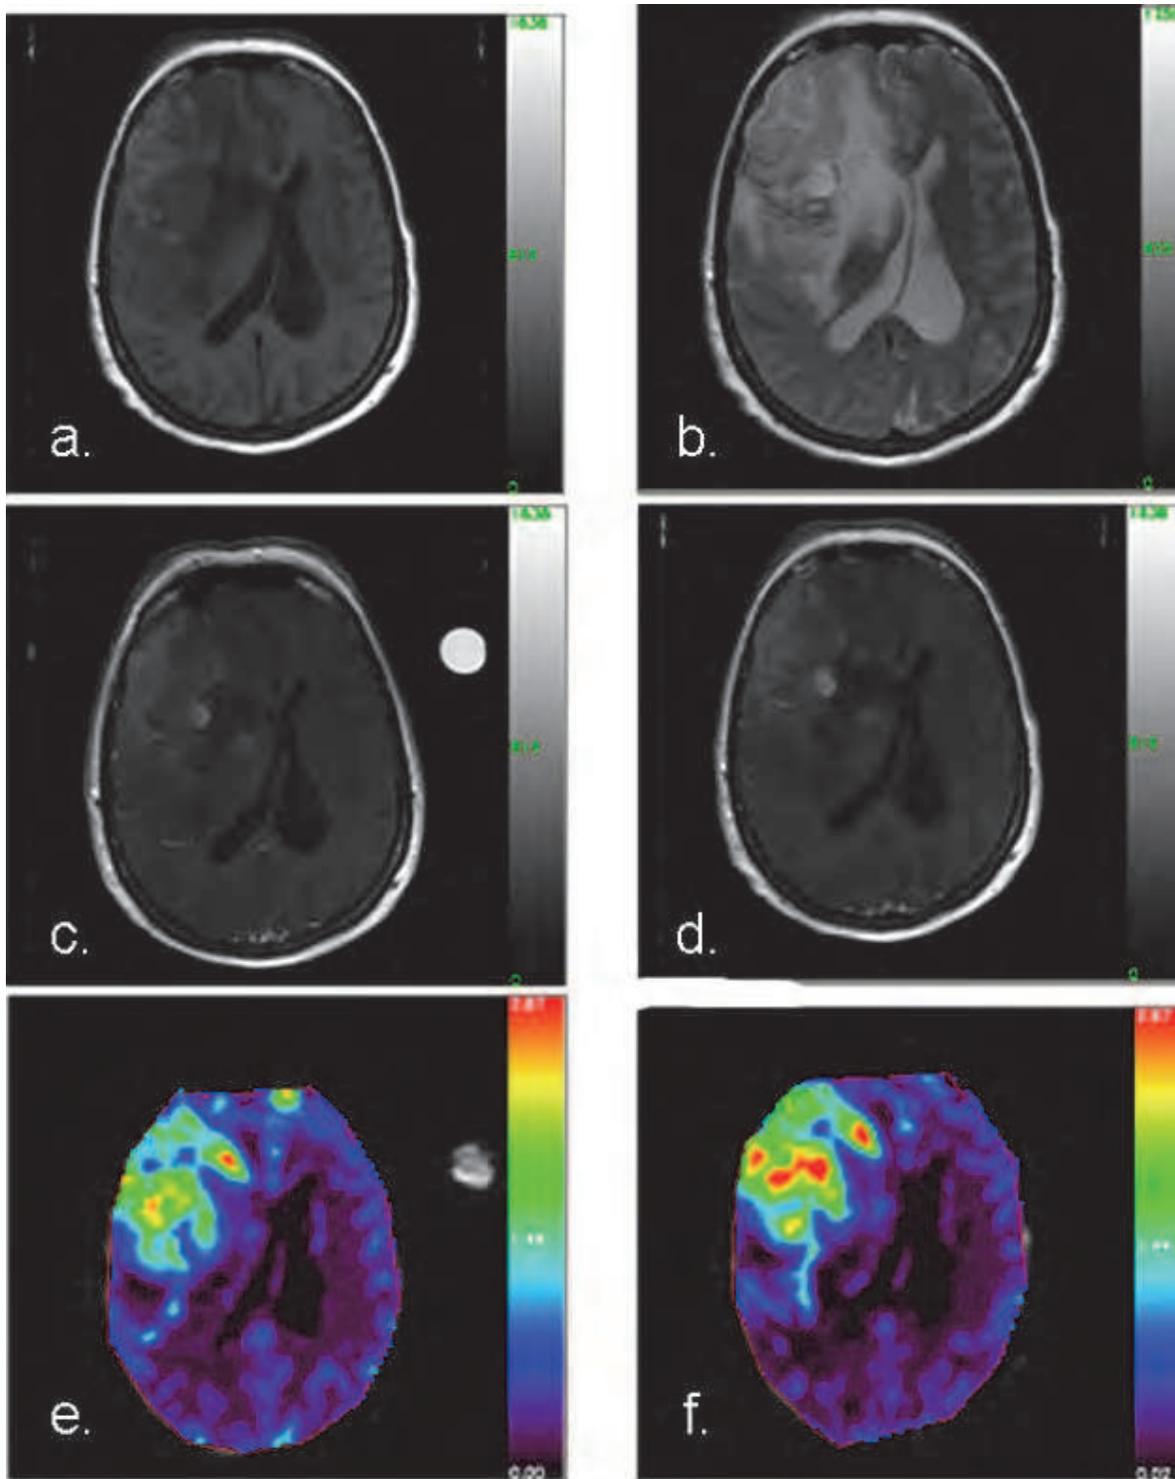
a) T1-weighted; b) T2-weighted; c) T1-w post Gd-DTPA contrast; d) T1-w post Gadobutrol contrast; e) T2* weighted parametric CBV map with Gd-DTPA; f) T2* weighted parametric CBV map with Gadobutrol. Gadobutrol is shown to be more sensitive and show more number of active lesions in tumour with high blood supply.[4].
